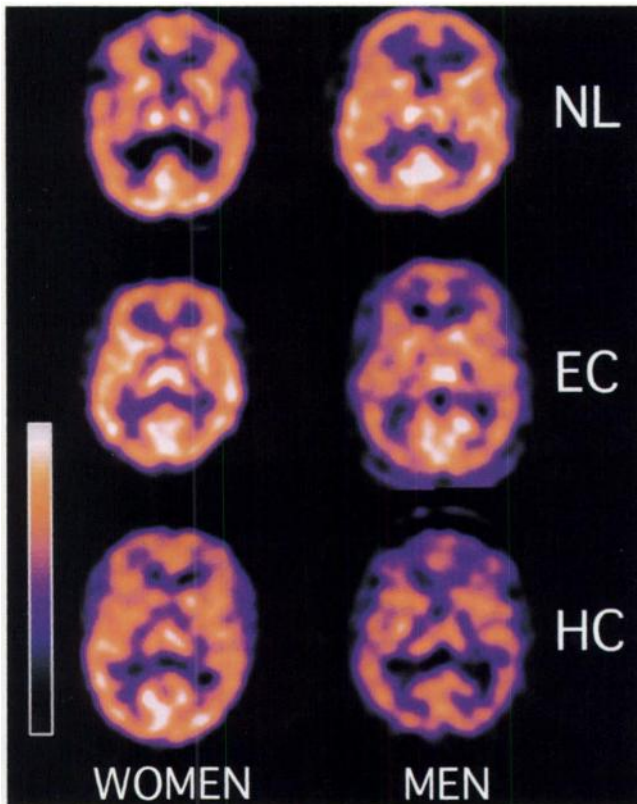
Comparison of brain SPECT images of women and men in each clinical category. Comparable midcortical slice (5-mm thick), including basal ganglia, thalamus, frontal, temporal, parietal and visual cortex. NL = normal control; EC = exclusive cocaine user; HC = concurrent cocaine and heroin user.
